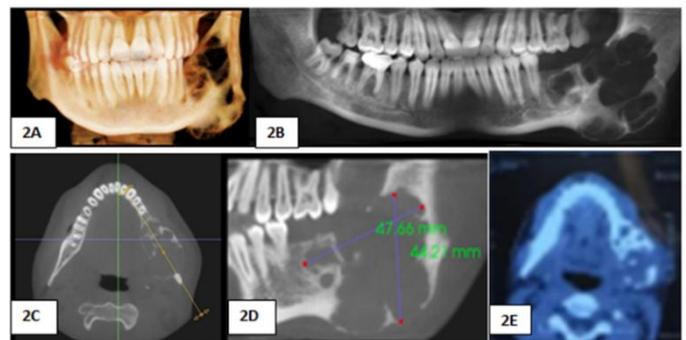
A shows 3 dimensional CBCT of the lesion, 2B shows panoramic view showing multilocular lesion, 2C shows cross sectional axial CBCT of the lesion, 2D shows Sagittal cross sectional image, 2E shows axial image of the CT scan
